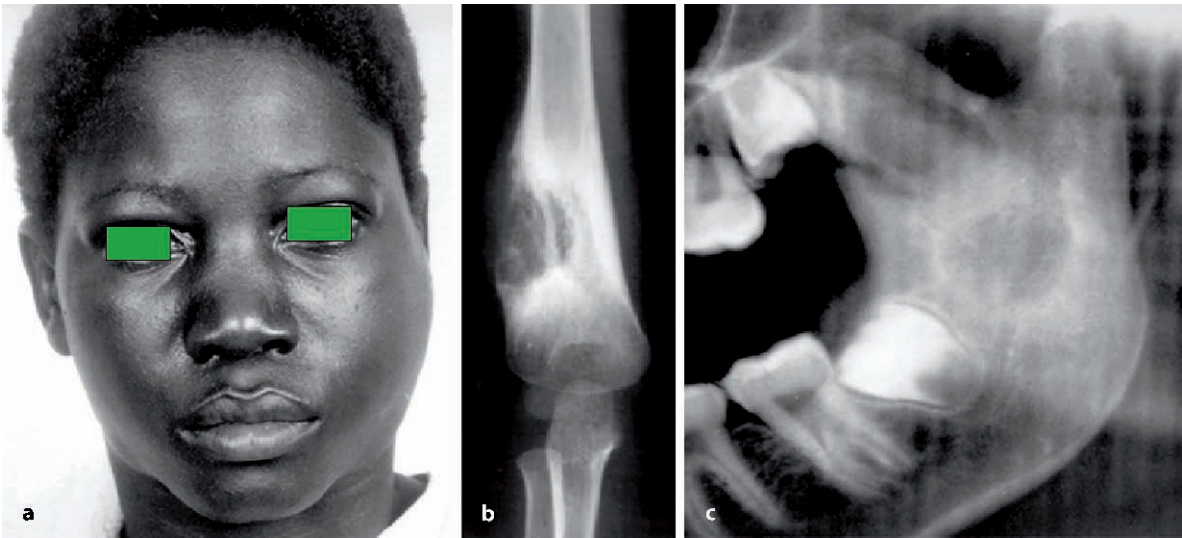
Tuberculous osteomyelitis. a Facial swelling is a frequent feature of this uncommon presentation of tuberculosis. b Tuberculous osteomyelitis of long bone causing loss of cortical continuity. c Detail from panoramic radiograph shows irregular radiolucency below the mandibular notch (tuberculous osteomyelitis)
